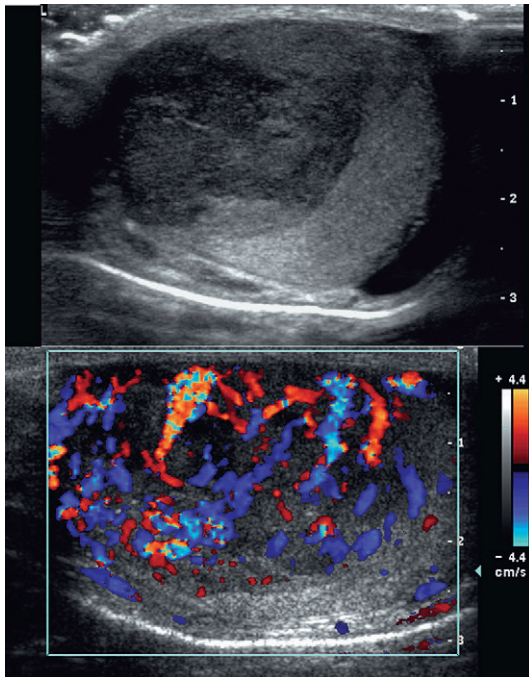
Longitudinal images of a testis being evaluated for a palpable mass. The large hypoechoic irregular mass replaces the majority of this testis. The colour Doppler image shows marked hyperaemia throughout this large mass. Note the distorted vascular architecture indicates tumour neovascularity.
